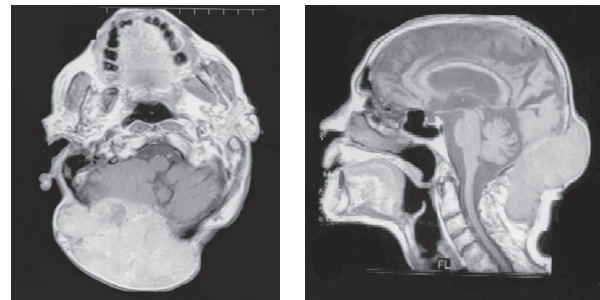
(Left) Axial computed tomography scan of the head showing a large soft-tissue mass involving the right occipital bone, with extension to the overlying soft tissues.
